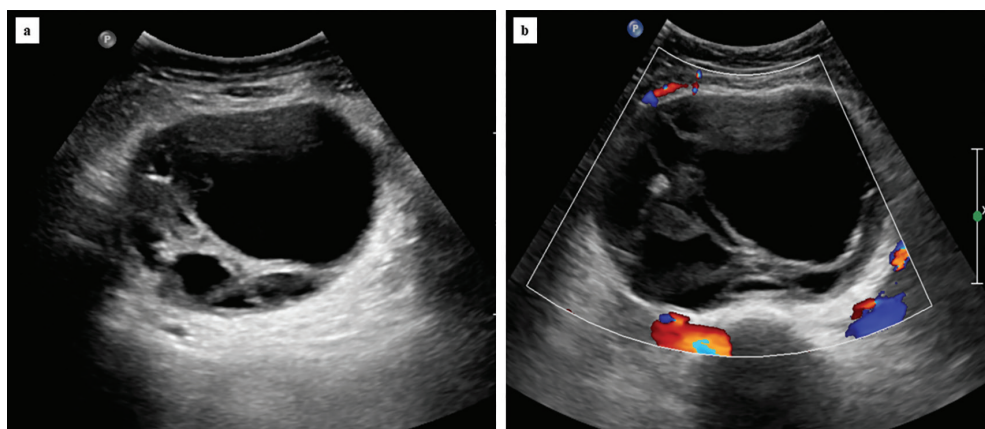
(a) Axial ultrasound image-large thick-walled multiloculated cystic lesion with thick internal separations; (b) On colour Doppler, minimal uptake is noted only in the wall of the lesion
